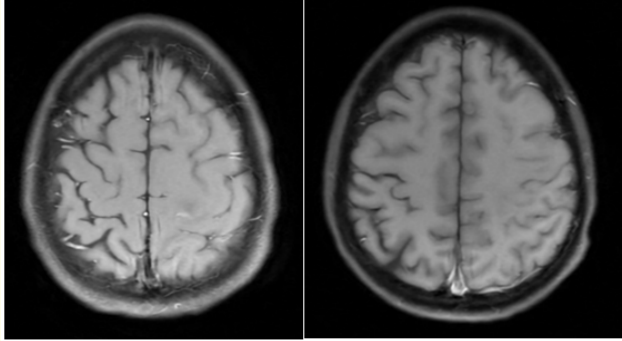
There is still residual cortical thickening over the left cerebral hemisphere but already improved compared to the cranial MRI pre-MPPT.
